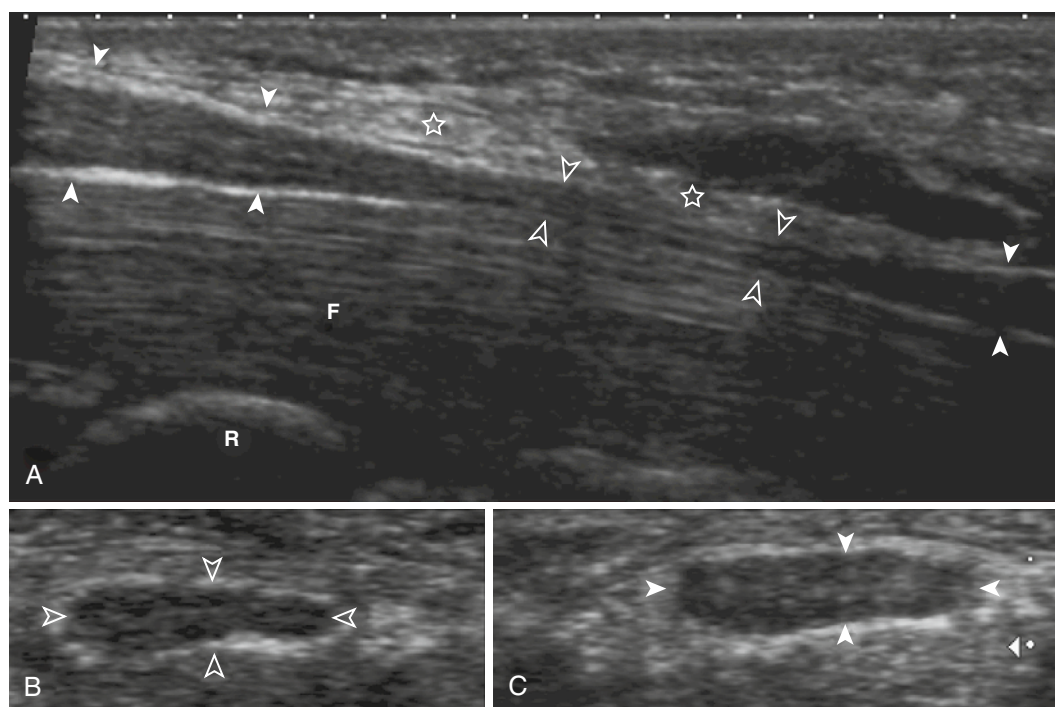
CARPAL TUNNEL SYNDROME. A, Long-axis, 5- to 14-MHz ultrasound image obtained over the palmar aspect of the wrist shows the enlarged and hypoechoic proximal and distal median nerve (*closed arrowheads*) before an area of thinning of the nerve (*open arrowheads*) when it passes under the flexor retinaculum (*stars*). The corresponding short-axis ultrasound image (C) of the enlarged median nerve (*closed arrowheads*) with a cross-sectional area of 15 mm² should be compared with the normal, short-axis ultrasound image of the contralateral median nerve (*open arrowheads*) (B). F, flexor digitorum tendons; R, radius.
